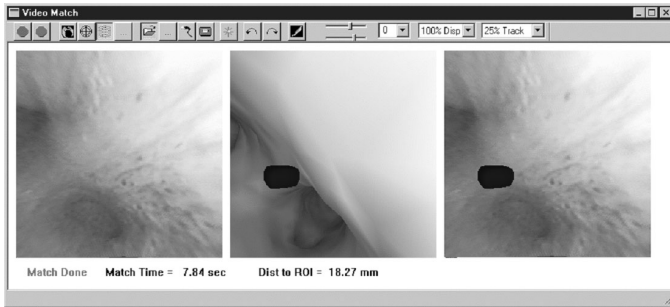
The Video Match Tool. On the left is the live endoscopic video stream. In the center is the matching virtual endoluminal rendering from the 3D CT data. The matched endoscopic video view is on the right with a rendered target site (from the registered CT) drawn on it.
